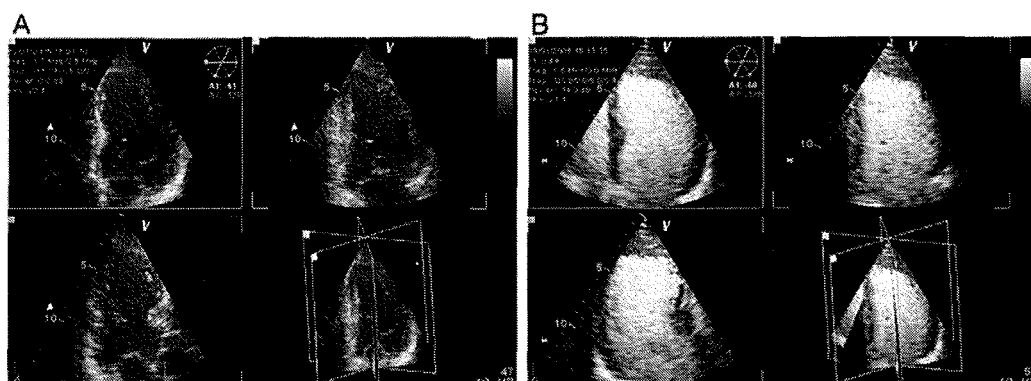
Simultaneous triplane echocardiography from patient before (A) and after (B) intravenous contrast administration. Three apical views are displayed in quadview with 4-chamber reference view (*top left*). Interplane angles are 60 degrees. *Bottom right*, Interposition of imaged planes.
